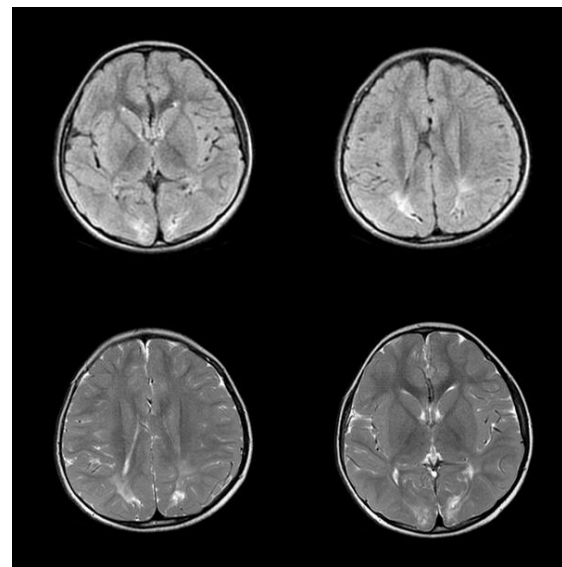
A 5-year-old boy, a known case on B –ALL presented with drowsiness, irritability following chemotherapy. MRI scan was performed, T2 and FLAIR hyperintense signal intensity was noted in bilateral fronto-parietal lobes.
